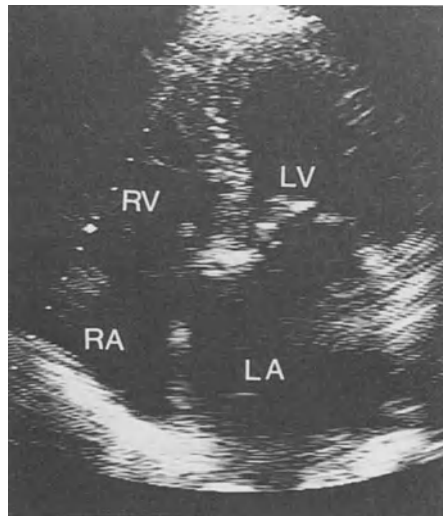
2D Echocardiogram: Apical four chamber view; mitral stenosis, showing doming of thickened leaflets and enlarged left atrium.
